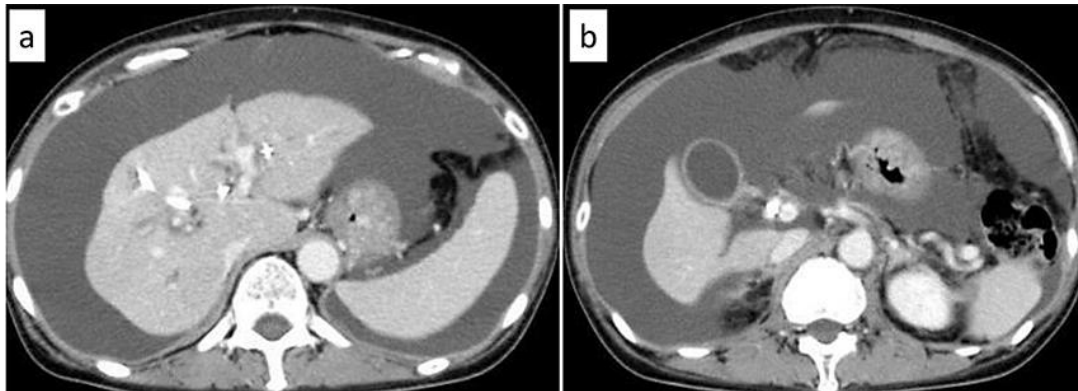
a, b CT showed large amount of ascites, periportal collar sign, and right ureteral stenosis due to peritoneal dissemination.
